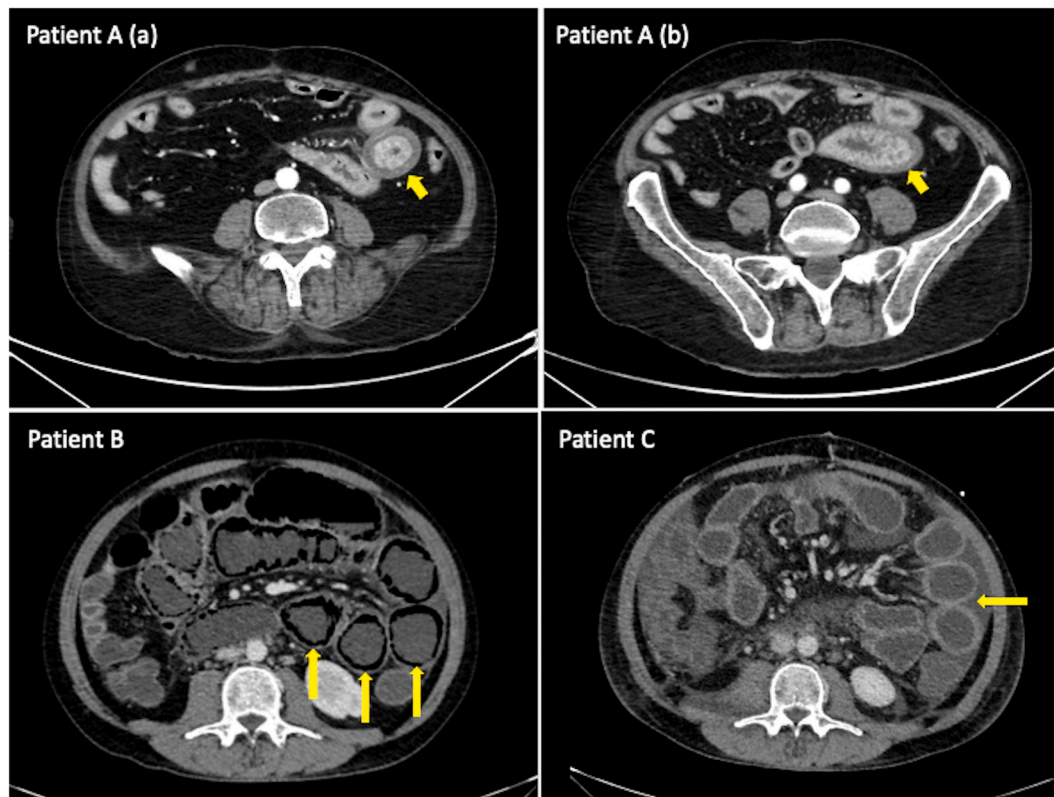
Contrast enhanced abdominal CT-scans of neutropenic enterocolitis.
